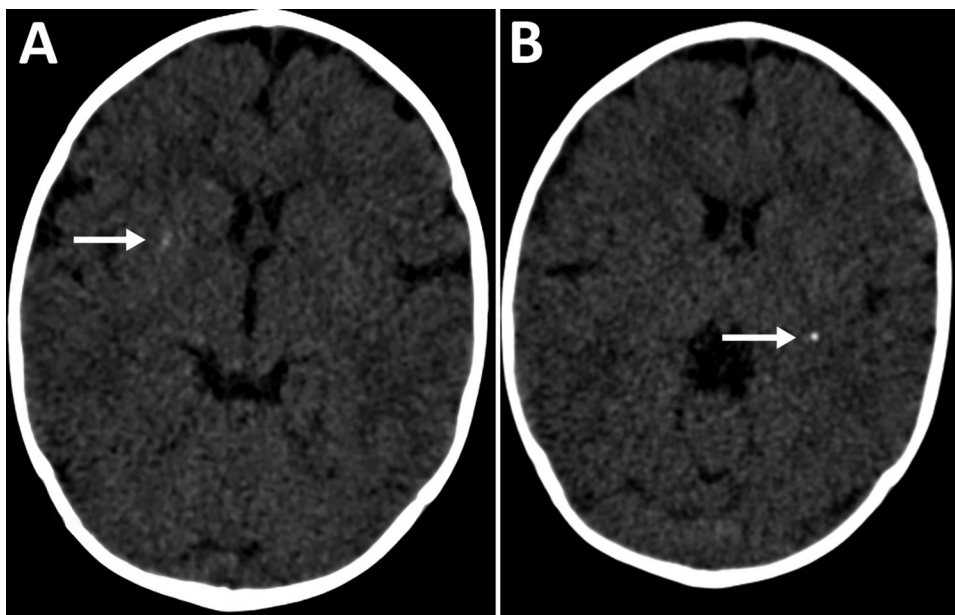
Cerebral computed tomography images of infant with probable congenital Zika virus infection at 7 months of age, Brazil. A) Mild calcification at the right lenticular nucleus (arrow); B) calcifications at the posterior arm of the left internal capsule (arrow).
